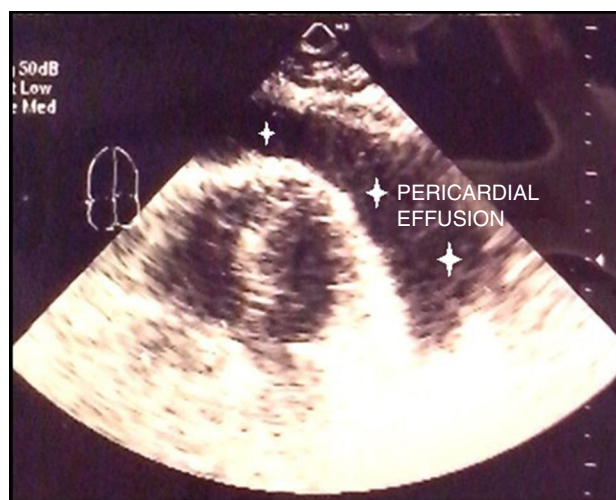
Echocardiogram showing massive pericardial effusion (stars).
